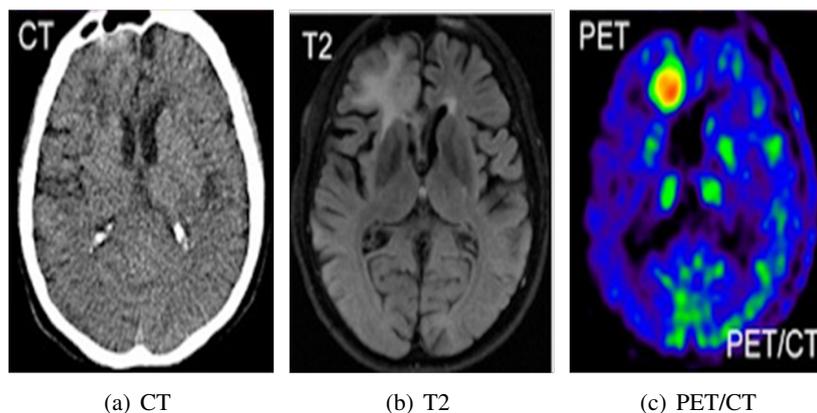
Multi-modality maps, (a) is the noncontrast-enhanced CT, (b) shows T2-weighted FLAIR image and (c) is PET/CT data.
